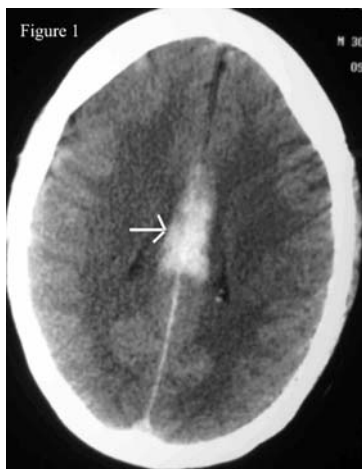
Non-contrast CT of head axial section showing pericallosal bleed.
